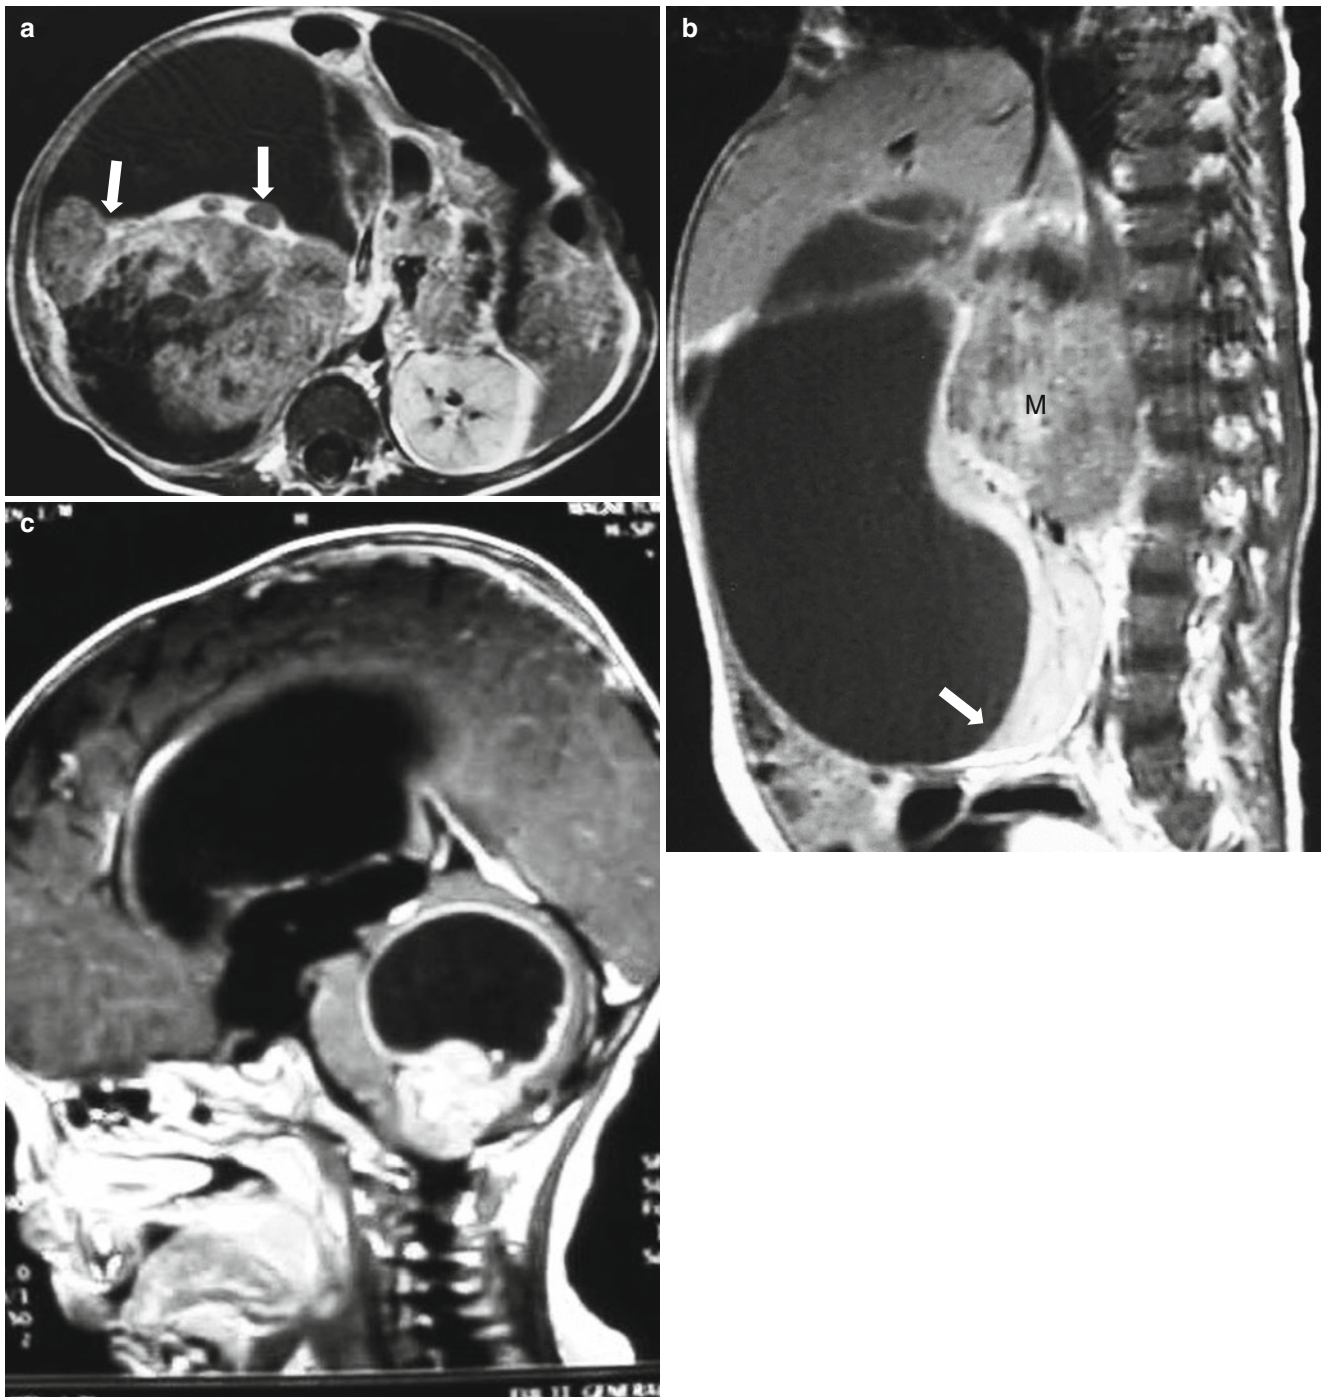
Rhabdoid tumor of the kidney in an 8-month-old boy. (a) T1-weighted axial MR image shows a heterogeneously contrast-enhanced mass. Note the large subcapsular hematoma and stretched renal parenchyma (*white arrows*). (b) Contrast-enhanced T1-weighted sagittal MR image shows a poorly contrast-enhanced mass (*M*) arising
